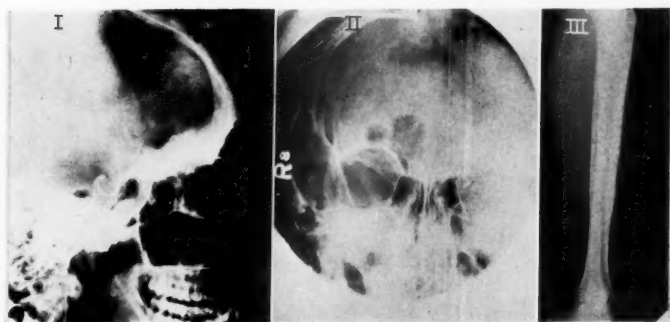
X-ray films of Case 8. Film I was taken on March 3, 1942. There is a large defect in the temporal area while the rest of the bone is sclerotic and thickened by newly formed bone.
